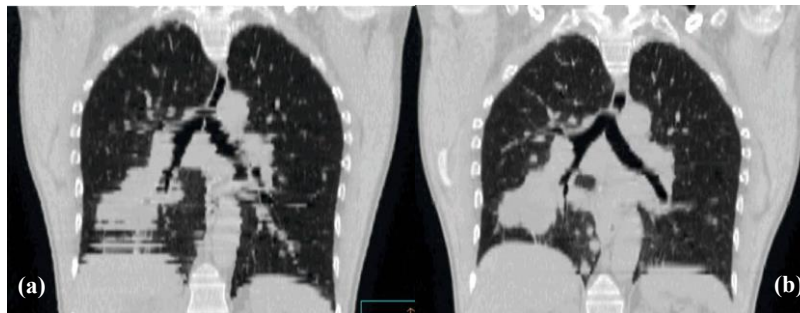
Coronal view CT scan during free breathing (a) and respiratory gated (b)
